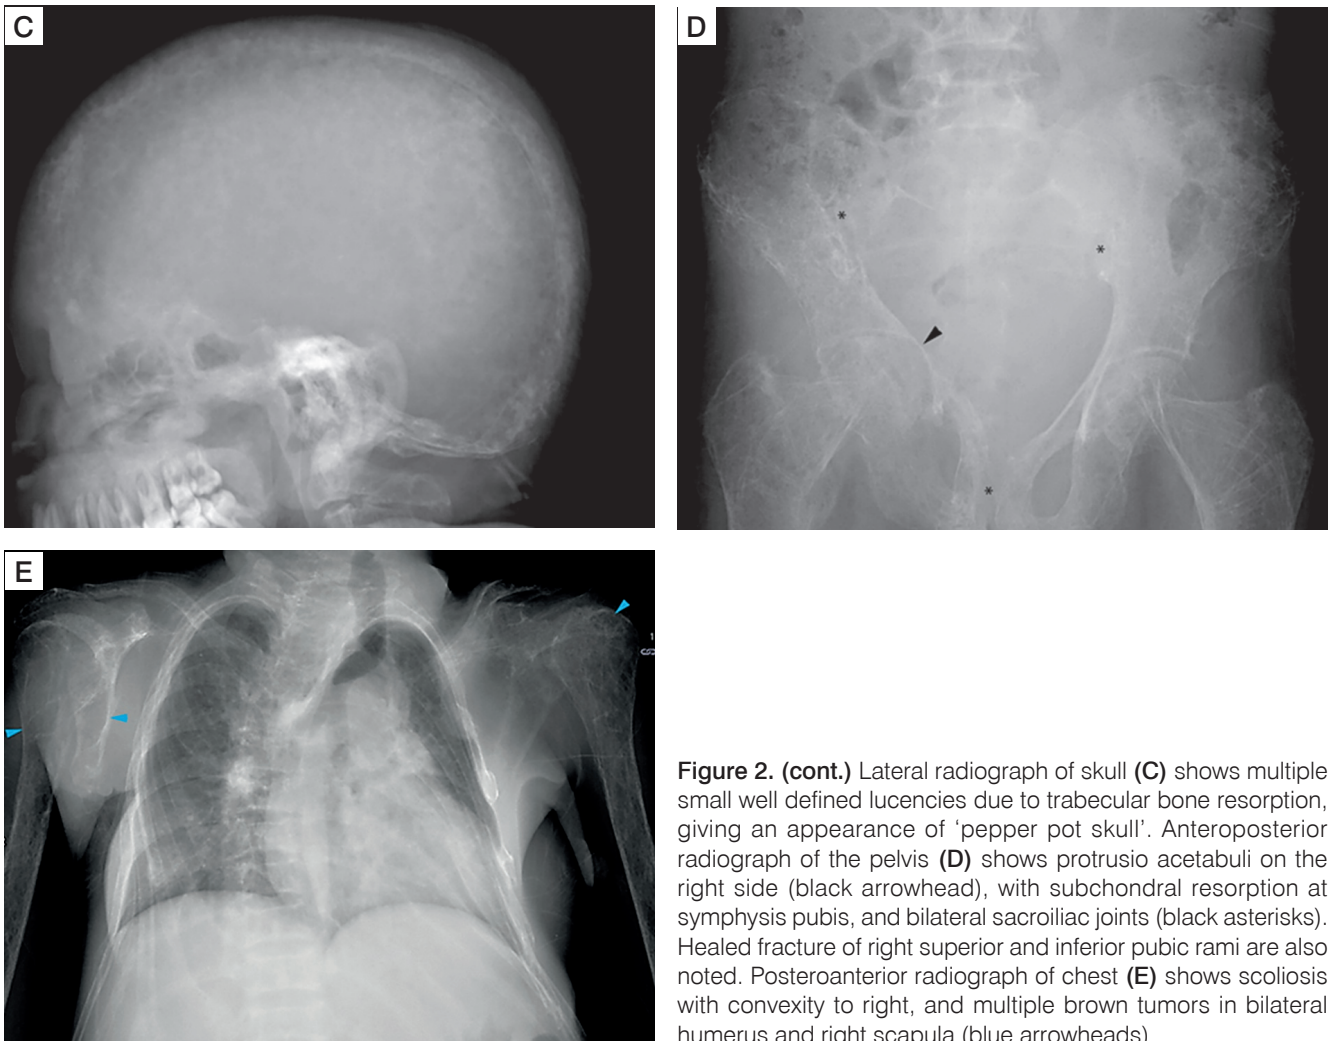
(cont.) Lateral radiograph of skull (C) shows multiple small well defined lucencies due to trabecular bone resorption, giving an appearance of 'pepper pot skull'. Anteroposterior radiograph of the pelvis (D) shows protrusio acetabuli on the right side (black arrowhead), with subchondral resorption at symphysis pubis, and bilateral sacroiliac joints (black asterisks). Healed fracture of right superior and inferior pubic rami are also noted. Posteroanterior radiograph of chest (E) shows scoliosis with convexity to right, and multiple brown tumors in bilateral humerus and right scapula (blue arrowheads)
